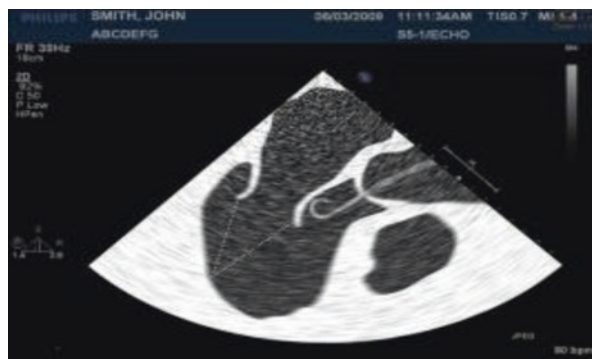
Impella catheter too far out of the left ventricle on transesophageal echocardiogram
